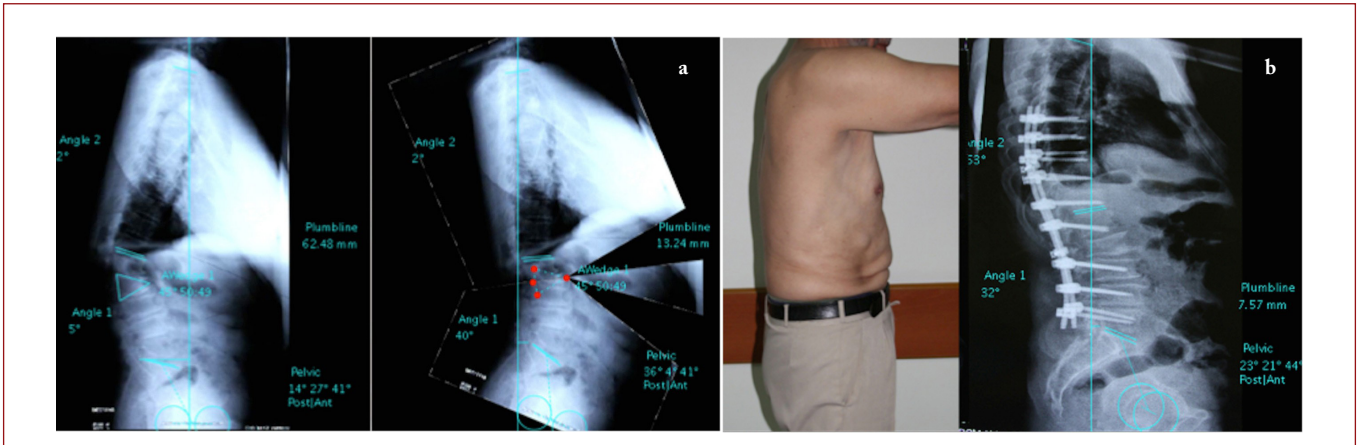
a) 65-year-old man, sequelae of a thoracolumbar fracture, the plan of an apical PSO and adjacent single or two-level SPO can be seen, showing that with three-level osteotomy, the pelvis and sagittal balance will be overcorrected; b) Postoperative X-rays showing the outcome after one PSO and one SPO.
